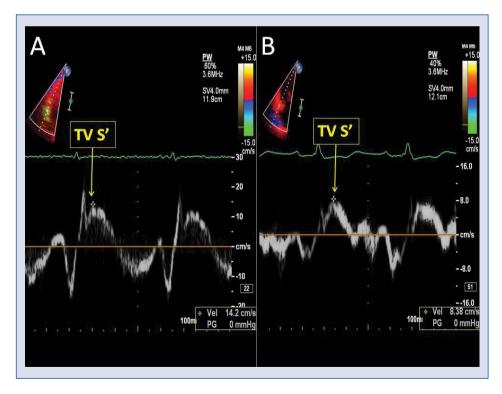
Tissue Doppler of the tricuspid annulus in two initially normotensive patients with acute pulmonary embolism; A. Patient with a benign clinical course (TV S' 14.2 cm/s — yellow arrow); B. Patient with a complicated clinical outcome and decreased annular velocity (TV S' 8.4 cm/s — yellow arrow); TV S' — peak systolic velocity of lateral part of tricuspid annulus.
